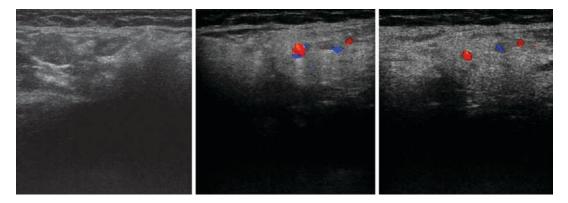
IPEH. (a) A gray-scale US showing a small, well-defined, oval, heterogeneously hypoechoic mass with an internal septum-like structure. (b) Oblique transverse color Doppler US showing moderate vascularity
